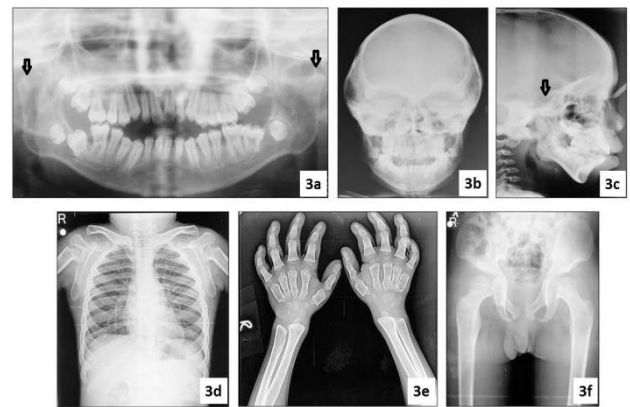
OPG shows hypoplastic mandibular condyles (arrow) (3a), PA skull shows mild thickening of the skull vault and bilateral protuberance over temporal region (3b), lateral ceph shows J-shaped sella turcica (arrow) (3c), chest radiograph shows abnormal shaped ribs (3d), hand-wrist radiograph shows bullet shaped metacarpals (3e) and pelvic radiograph shows flared iliac wings, inferior tapering of ilea and long and narrow femoral neck (3f).
